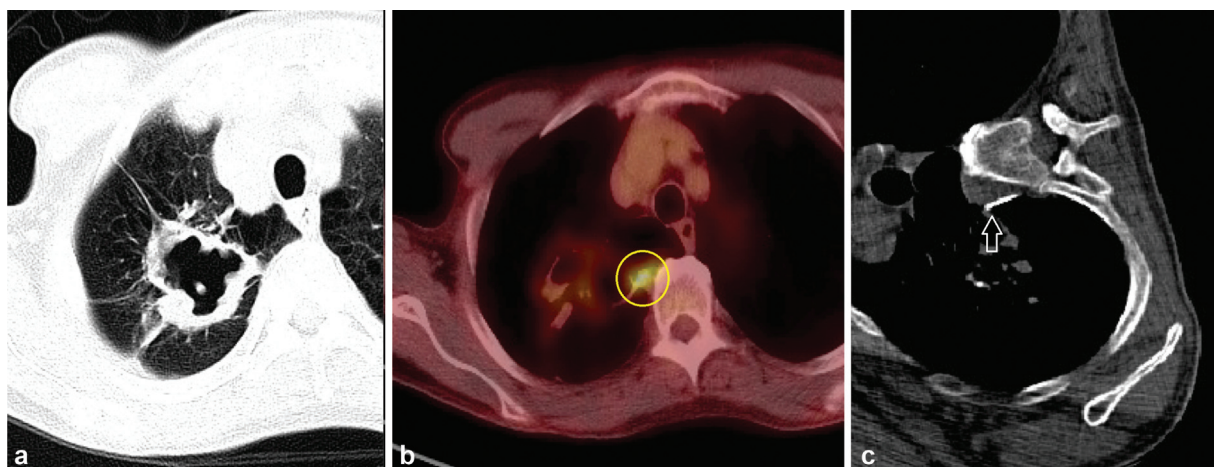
A 67-year-old with a cavitary right upper lobe mass (a) underwent PET-CT that showed FDG uptake in the medial component of the mass (b, circle), which was then targeted for the biopsy (c; arrow—needle tip). Pathology revealed nonnecrotizing granulomas.
